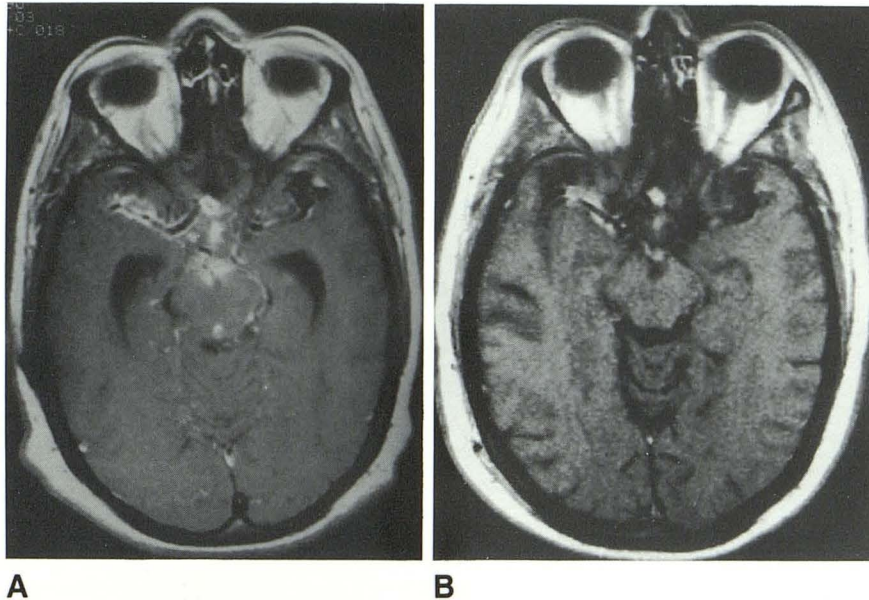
A and B, Patient 4; 40-year-old man receiving intensive intrathecal therapy. Improvement in meningeal enhancement seen on Gd-DTPA-enhanced T1-weighted (600-700/20) axial images during 18 months therapy (A, baseline; B, 18 months later).
